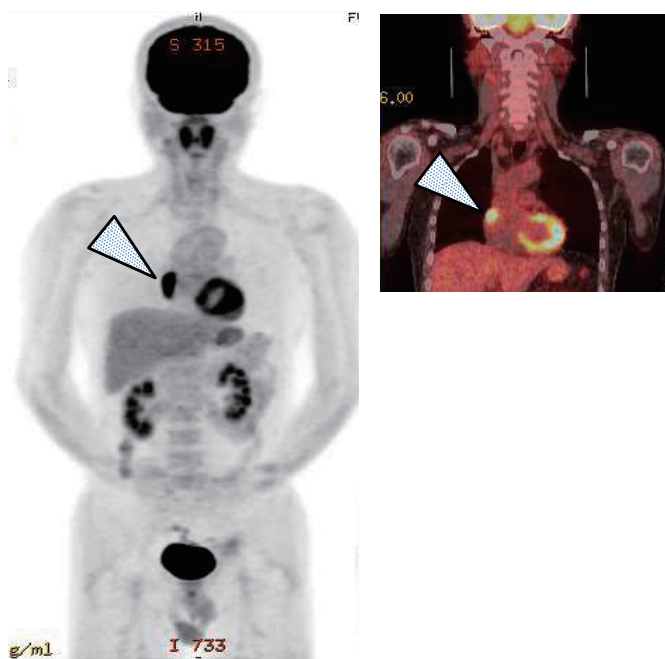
¹⁸Fluorine-labeled fluorodeoxyglucose positron emission tomography (FDG-PET)-CT showed hypermetabolic activity in the right atrium at presentation (arrowheads).
